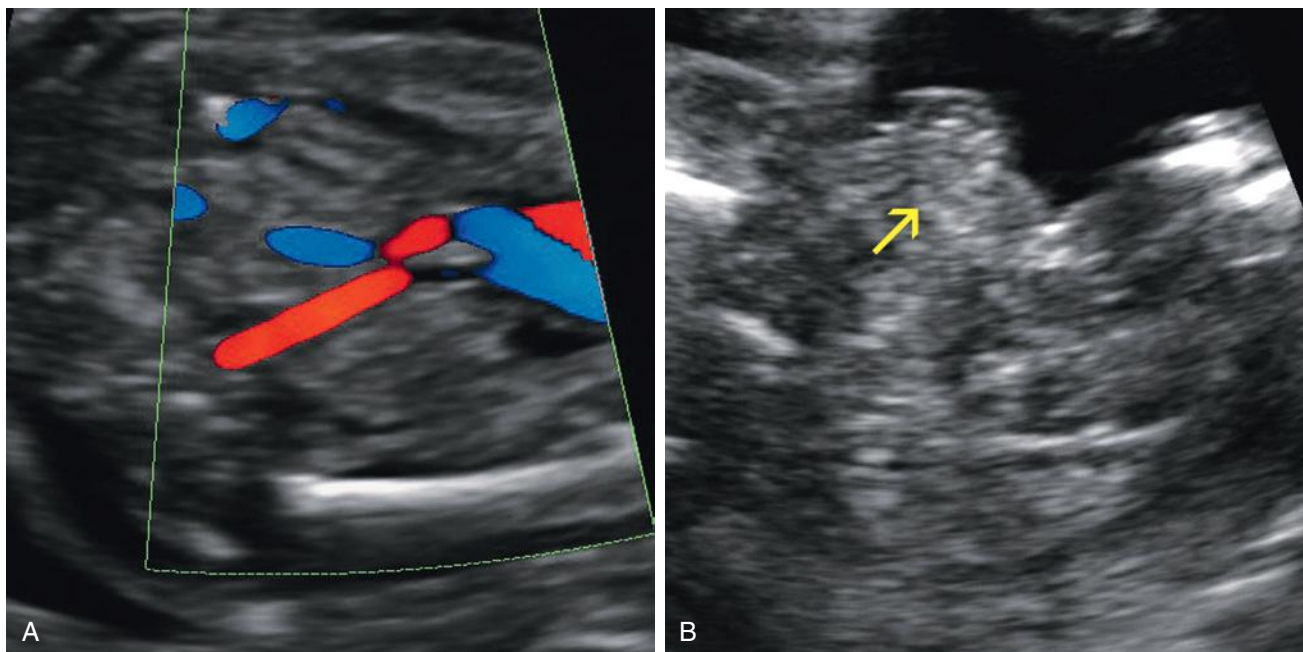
Bladder exstrophy. A, Color Doppler ultrasound image at the level of the umbilical arteries. The urinary bladder was not visualized and could not be identified on repeated attempts during a prolonged examination. The bilateral fetal kidneys and amniotic fluid volume appeared normal. This constellation of findings suggests bladder exstrophy. B, Exposed redundant bladder tissue (*arrow*) is noted at the ventral aspect of the inferior abdominal wall. Compare to [Figure 14-30A](#). This child underwent successful complete primary surgical repair.
